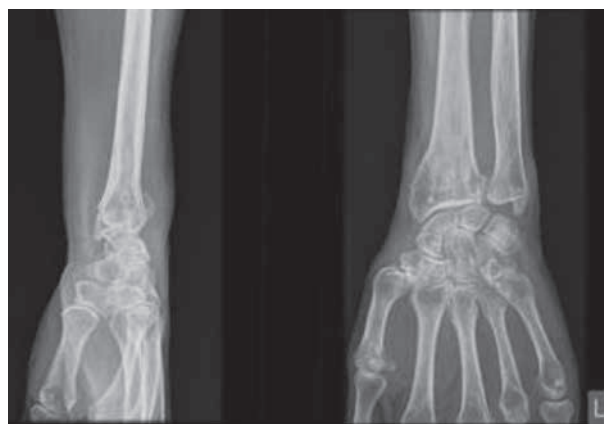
Case 2 (EA), x-ray distal radius lateral and AP view, female 78 y.
